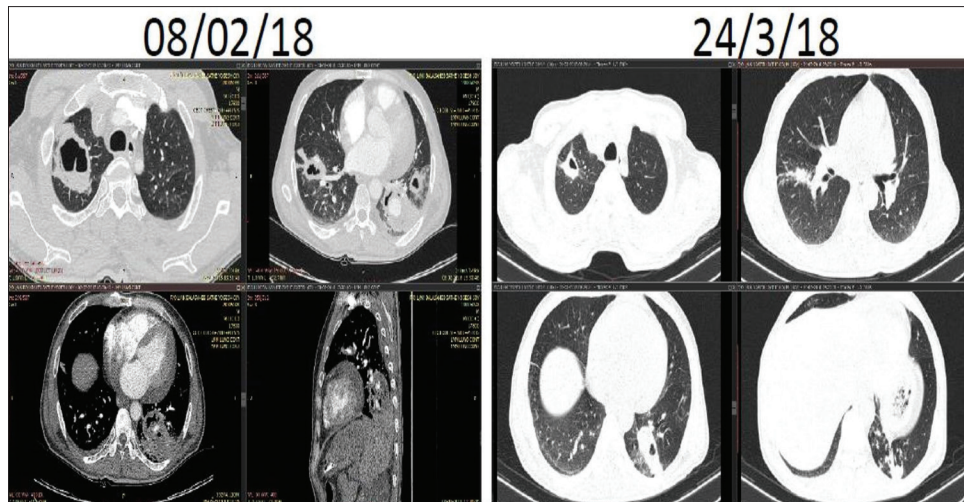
Computed tomogram of the chest showing significant regression of radiologic opacities after 6 weeks of treatment
